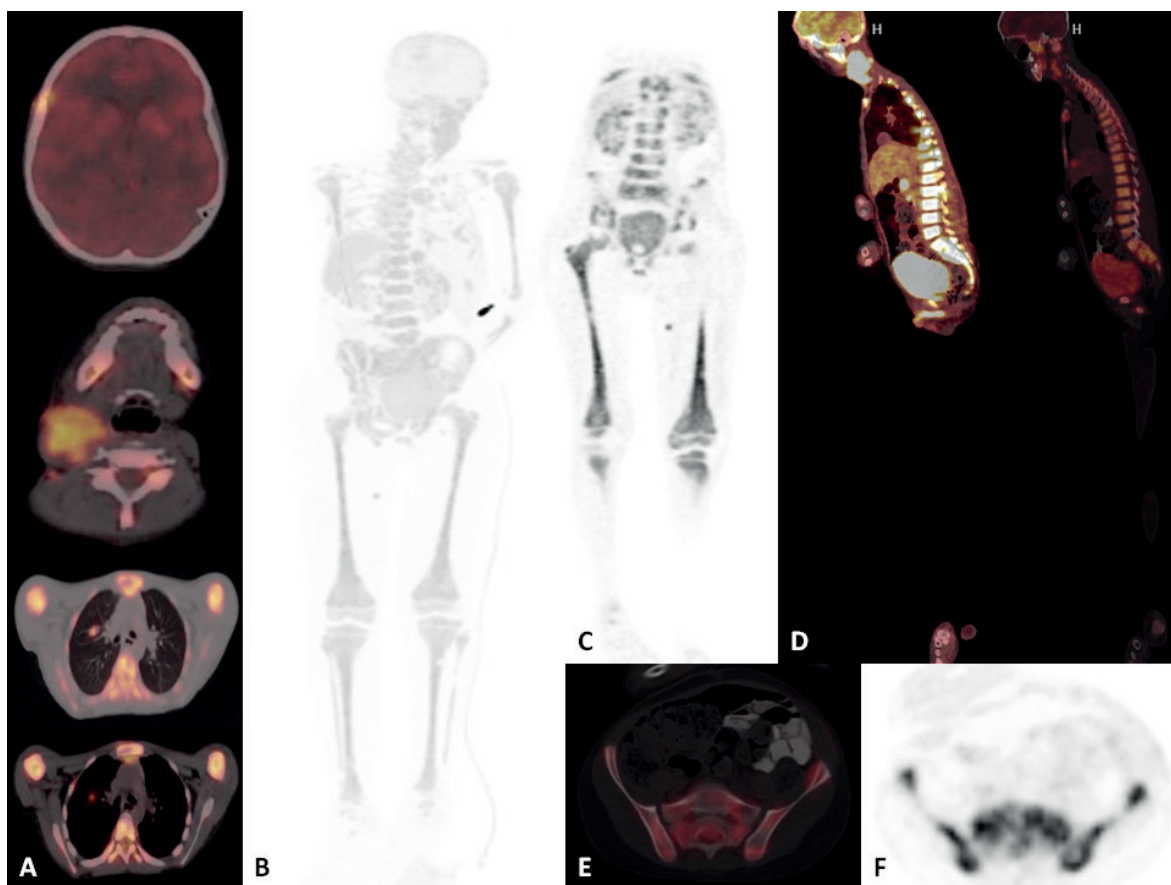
FDG PET-CT images of a 12 year old male patient with non-Hodgkin's lymphoma diagnosis. Axial fusion (A), Maximum intensity projection (MIP) image (B), coronal PET (C), sagittal fusion (D), axial fusion (E) and axial PET (F) images demonstrate multipl hypermetabolic lymphadenopaties, soft tissue lesions and bone-bone marrow diffuse and multifocal FDG uptake compatible with lymphoma diagnosis. Bone marrow biopsy was positive for this patient.
